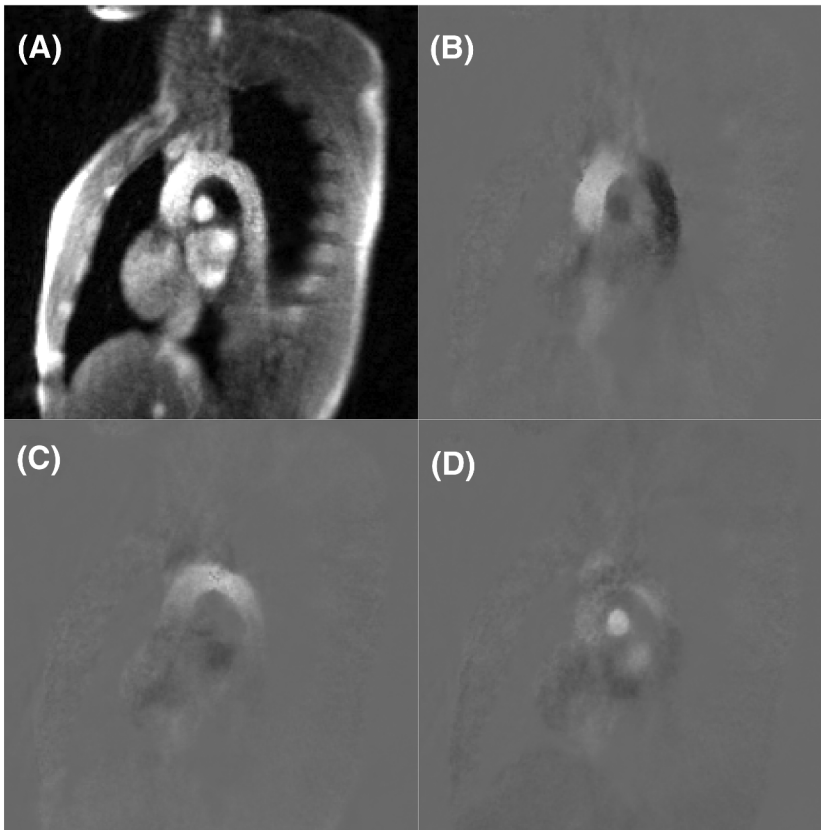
Peak-systolic frames of a real-time 3d flow MRI study of the aortic arch at 67 ms temporal resolution, i.e. 15 fps. (a) Magnitude image, (b) to (d) PC maps in foot-head, anterior-posterior and left-right (through-plane) direction, respectively
